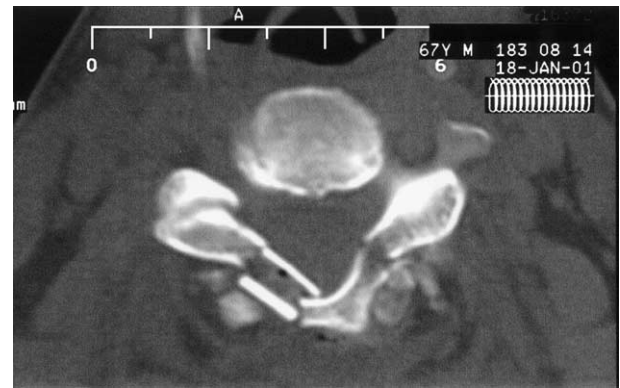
Postoperative axial computed tomography scan, bone windows, demonstrating the position of the rib allograft with respect to the opened lamina and facet resulting in an increased spinal canal volume.
